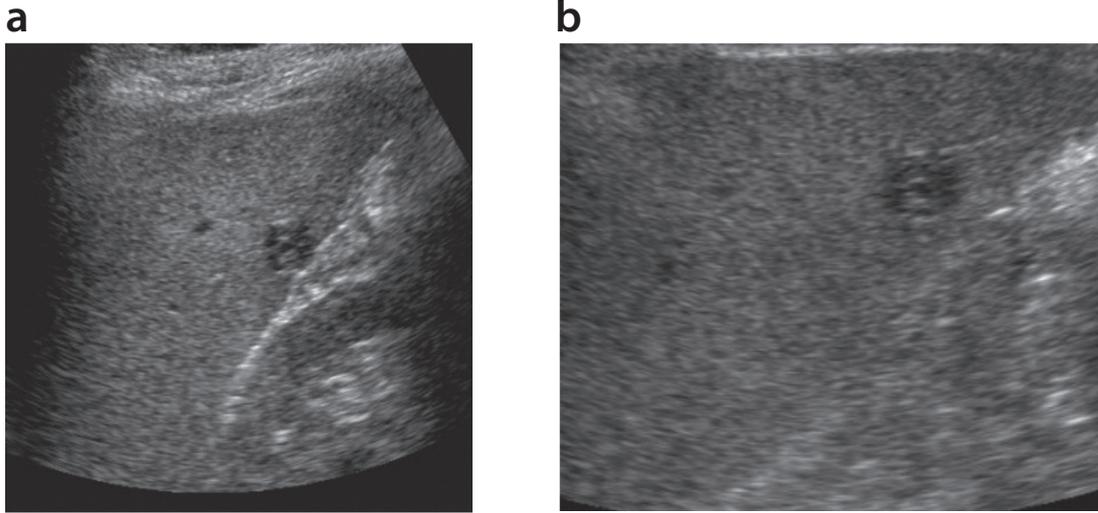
Appearance of Lesion on Abdominal Ultrasonography
